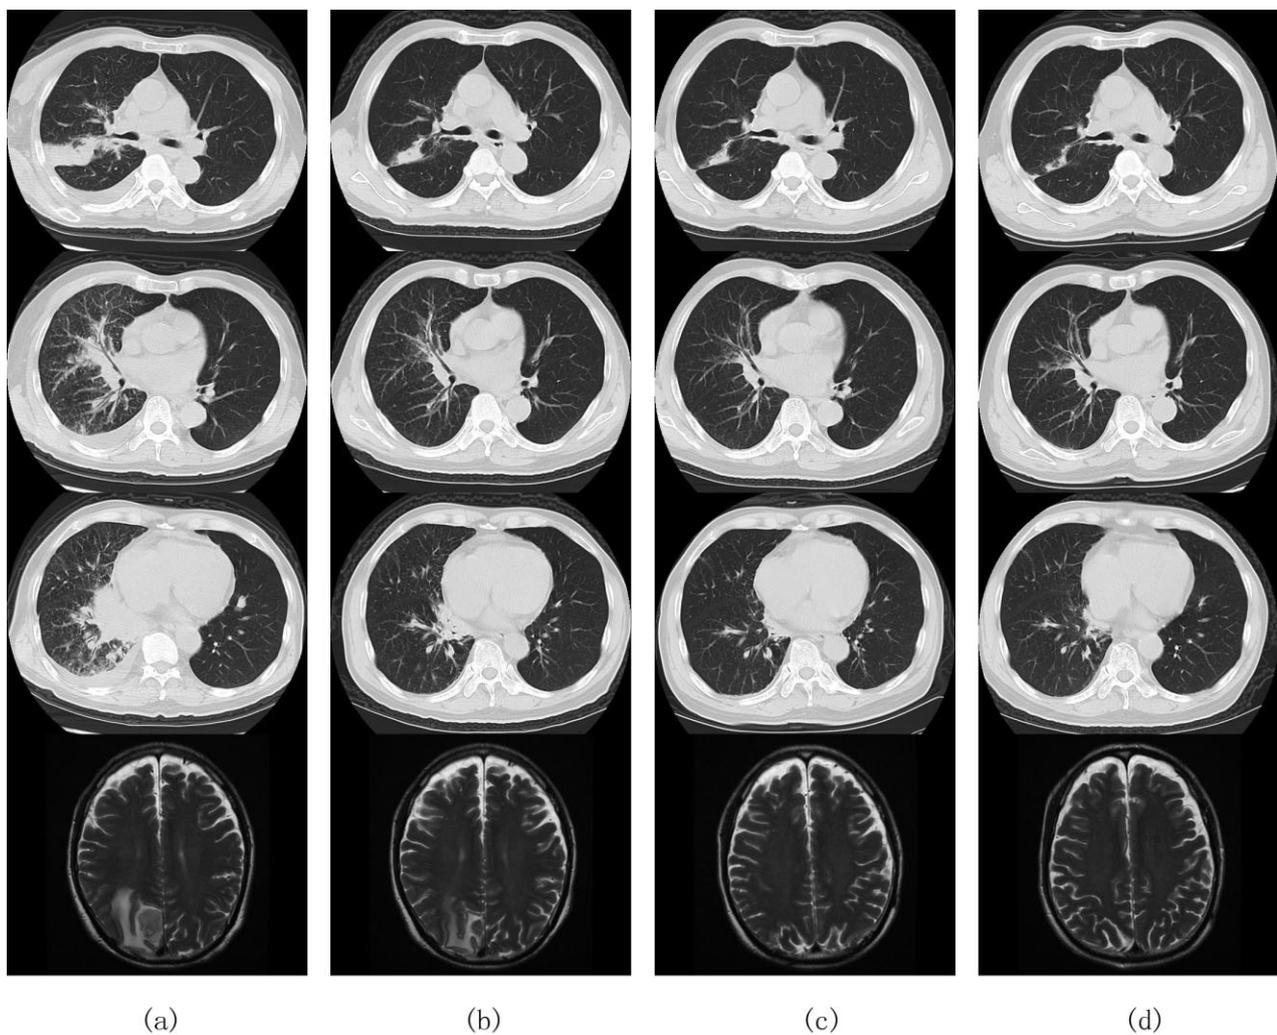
Chest computed tomography (CT) and brain magnetic resonance imaging (MRI) before and after treatment with icotinib. (a) Chest CT and brain MRI before icotinib treatment. (b) Chest CT and brain MRI one month after icotinib treatment. (c) Chest CT and brain MRI three months after icotinib treatment. (d) Chest CT and brain MRI five months after icotinib treatment.
